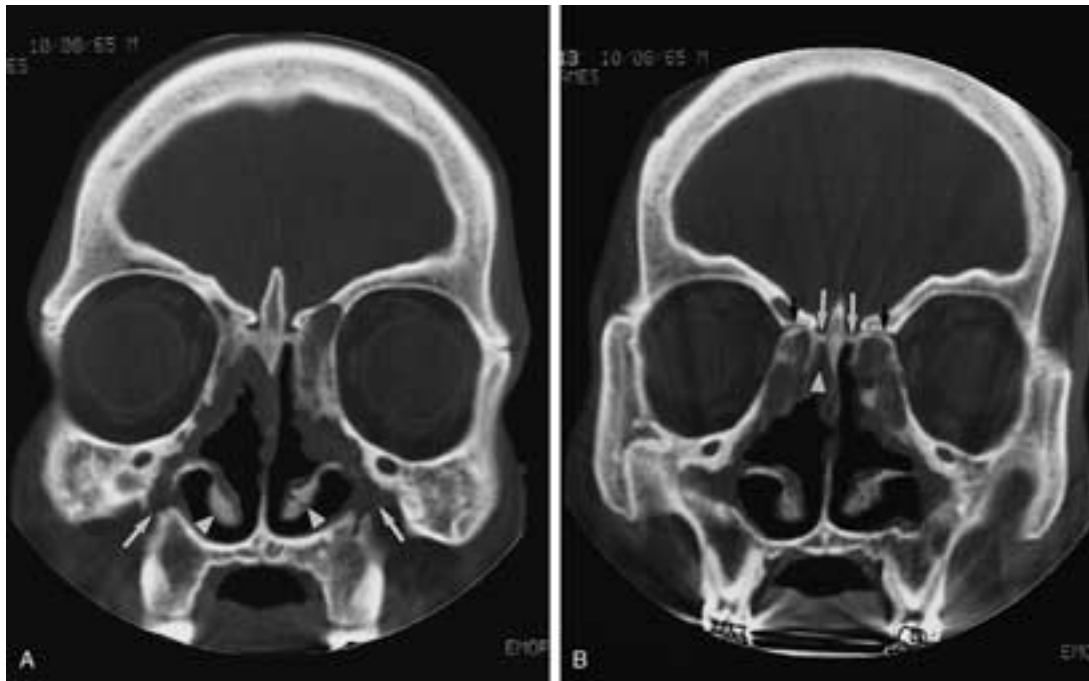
Recurrent polyposis. A, On this coronal CT scan, note the maxillary sinus hypoplasia, prior Caldwell-Luc defects (*arrows*), and diffuse recurrent mucosal thickening. There is extensive osteitis involving all the sinus cavity walls and even the bone of the inferior turbinates (*arrowheads*). B, Coronal CT scan posterior to A. Inflammatory mucosal changes are seen medial to the right middle turbinate (*arrowhead*). This area is almost never approached surgically, as injury to the perforated cribriform plate (*white arrows*) can result in CSF leak. The sinus walls are so dense and sclerotic that the anterior ethmoid artery canals (*black arrows*) are well seen.
